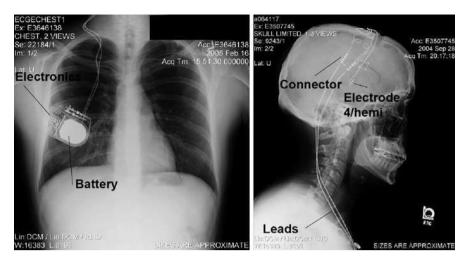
Anterior / posterior (*left*) and lateral radiographs showing implantable neurostimulator and stimulating electrodes targeting the anterior nucleus of the thalamus
